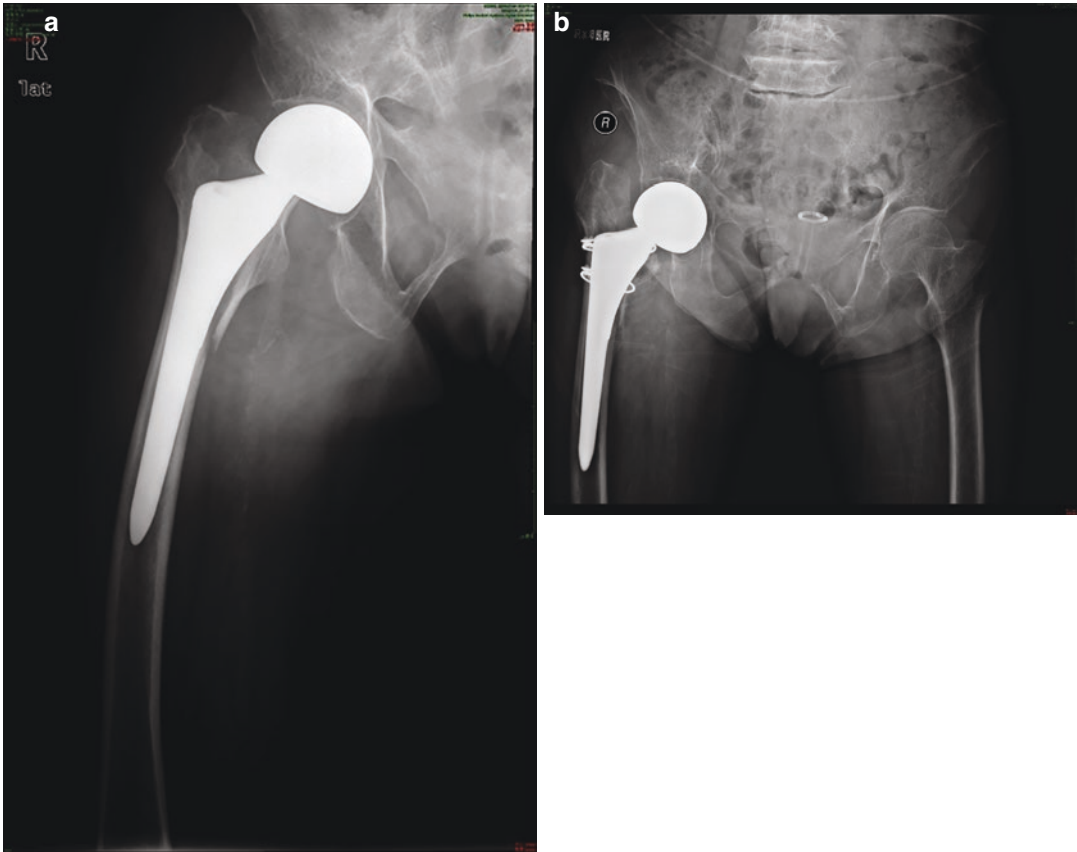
Radiograph of a periprosthetic femoral fracture type A2. (a) Preoperative image before revision (b) Postoperative image after cerclage wiring
